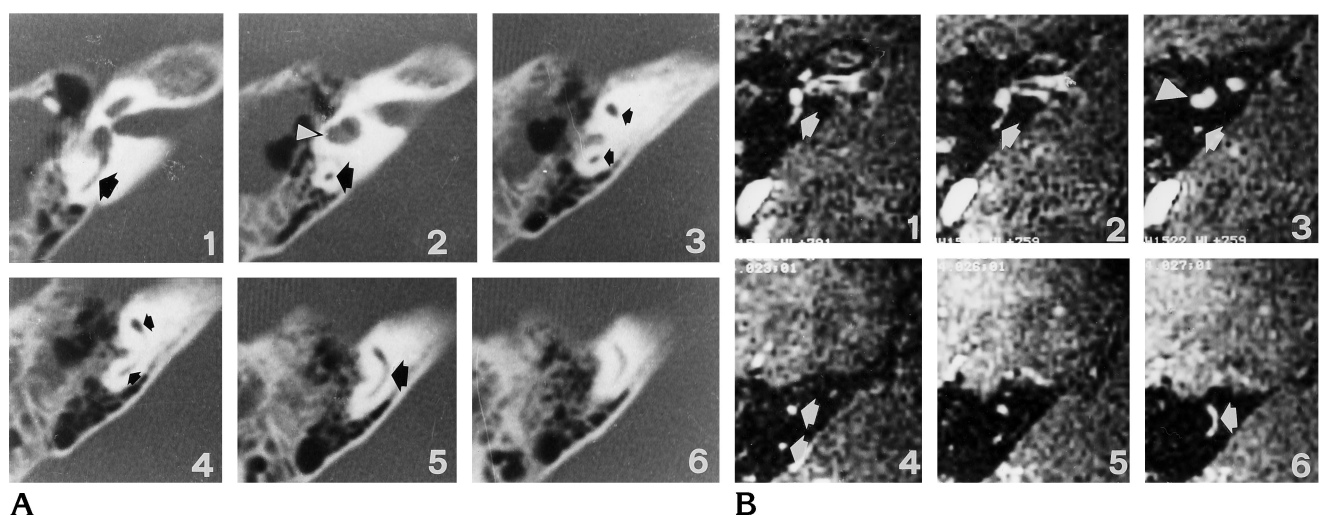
A 6-year-old boy with Goldenhar syndrome. Serial CT scans (A) and contiguous steady-state MR images (B), 1 to 6, of the right inner ear in the caudocranial direction, and 3-D maximum intensity projection reconstruction (C) of a sagittal view, with a normal labyrinth for comparison (D). The single posterosuperior semicircular canal is indicated by the *arrows* in A and B. At this stage, development of the lateral semicircular canal has not been completed, so a cystic lateral semicircular canal is also found (*arrowheads* in A and B). The round posterosuperior semicircular canal is seen better on the 3-D reconstruction (*arrowheads* in C). In a normal labyrinth (D), the common crus (*arrow*), shared by the superior (S) and posterior (P) semicircular canals, is always seen.
